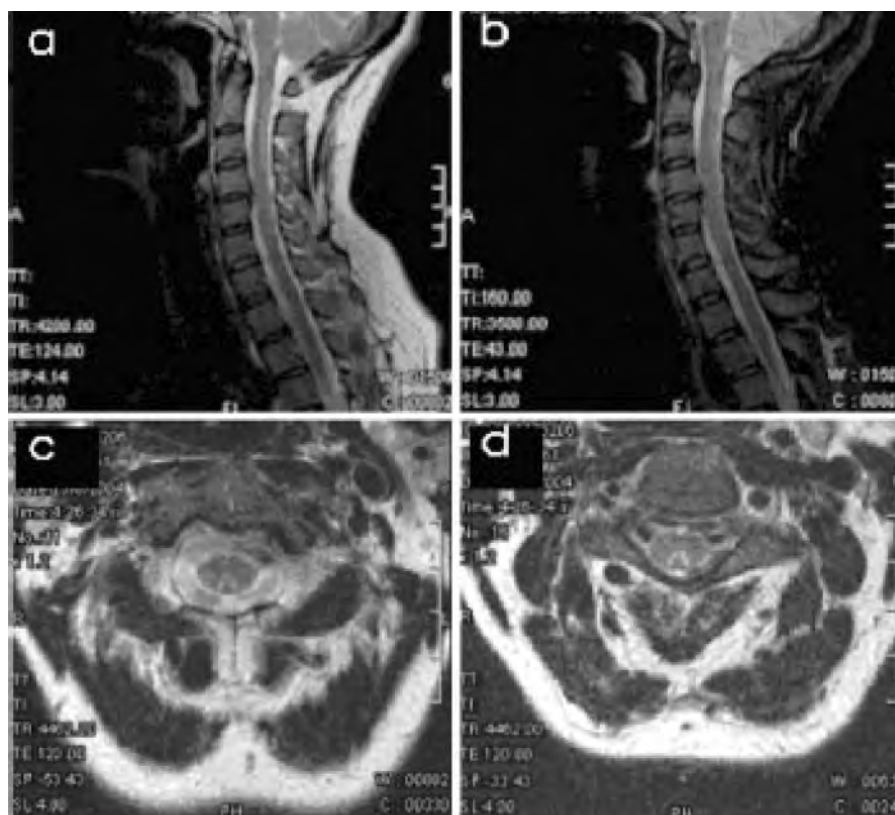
Sagittal and axial magnetic resonance images (MRIs) of cervical spine (T2-weighted) showing signal change in posterior columns in a case of subacute combined degeneration of the cord.
